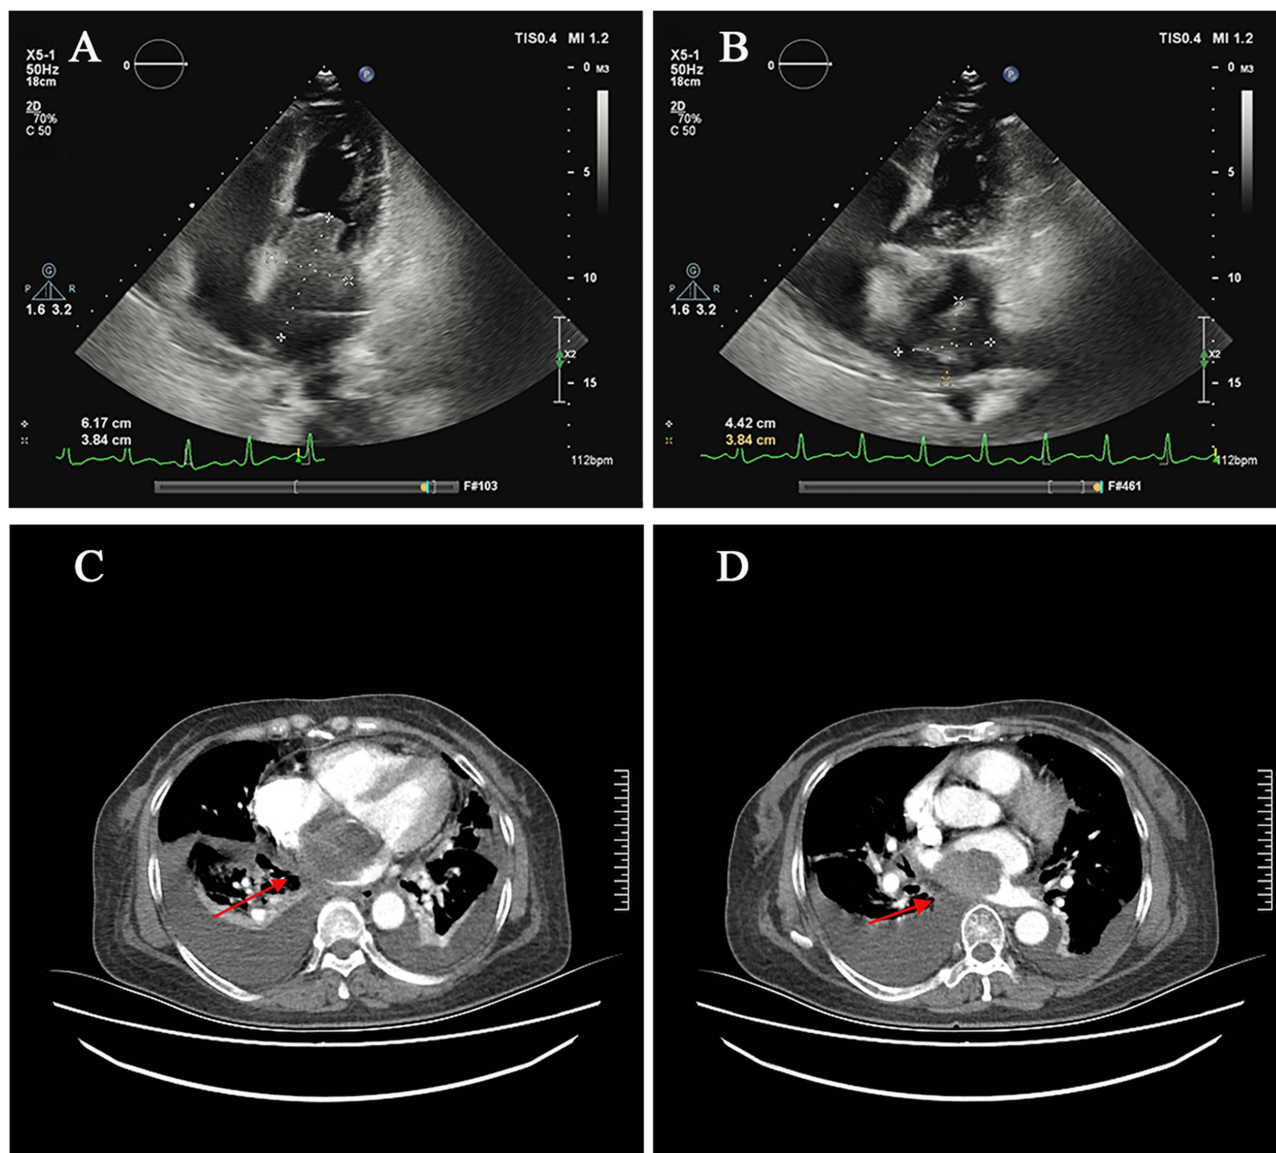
Preoperative multimodal imaging characteristics. (A and B) Transthoracic echocardiography reveals two slightly hypoechoic masses attached to the left atrial wall and the atrial roof. (C and D) Contrast-enhanced chest computed tomography (CT) demonstrates corresponding hypodense filling defects within the left atrium, exhibiting moderate, heterogeneous delayed enhancement.
